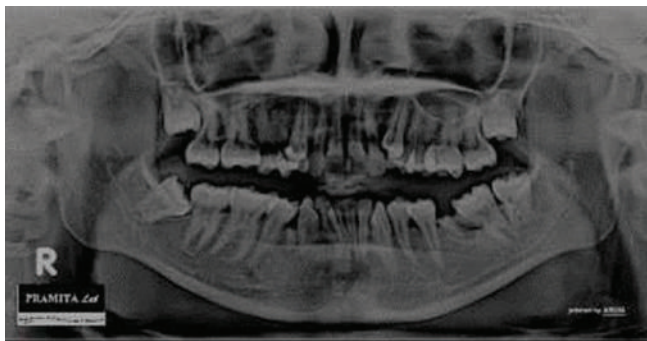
Patient's orthopantomogram.
